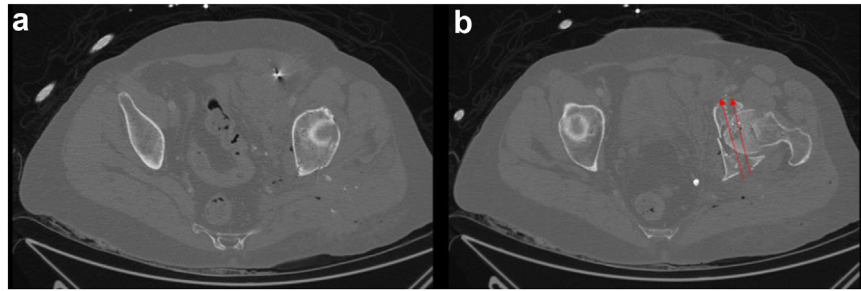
Axial CT scan demonstrating (a) a superior cross-section of the acetabular socket, which was affected by the posterior wall fracture, but without cavitory lesions from the projectile and (b) an inferior cross-section the path of the projectile, (represented by the 2 red arrows), from posterior to anterior, traversing the anterior wall, femoral head, and posterior acetabular wall.
